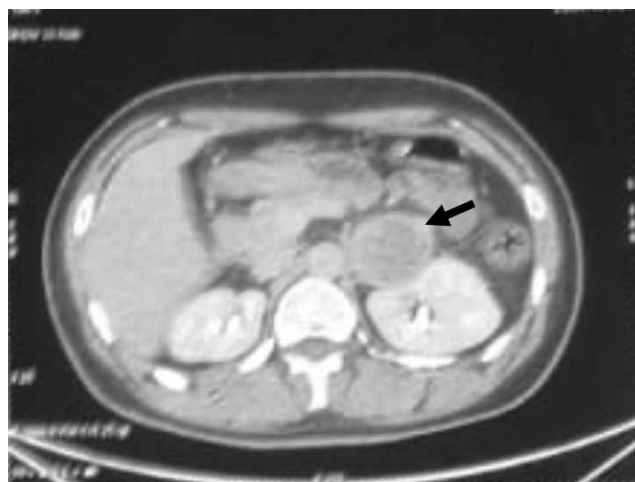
Noncontrast CT scan of abdomen showing left adrenal mass (solid arrow).
